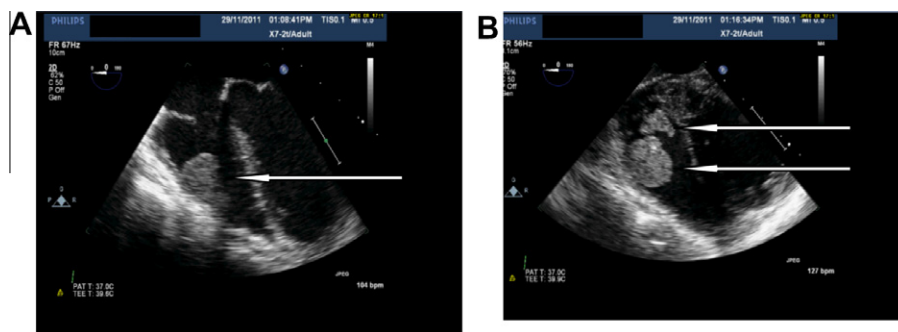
Transesophageal echocardiography showing RV mass. (A) Showing one mass and (B) showing 2 lobules.
